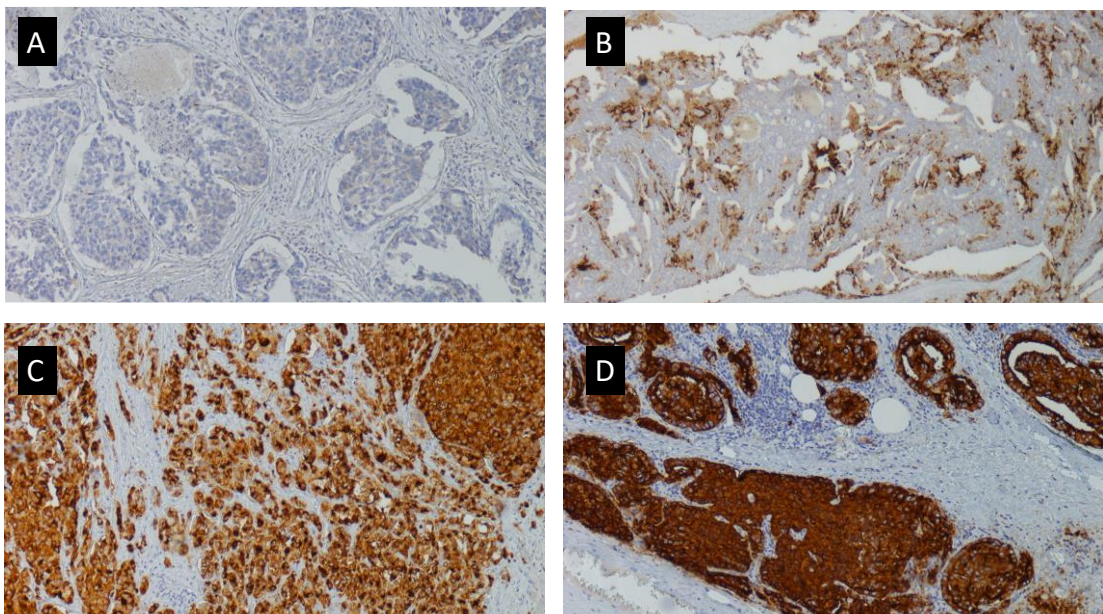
Difference of PSMA expression patterns among the evaluated patient cohort. Figure A shows a PCa with absence of any PSMA antibody uptake (PSMA 0). Figure B shows low PSMA expression pattern (PSMA 1+). Figure C shows moderate signal of PSMA Uptake (PSMA 2+). Lastly, Figure D shows intense PSMA uptake (PSMA 3+)
